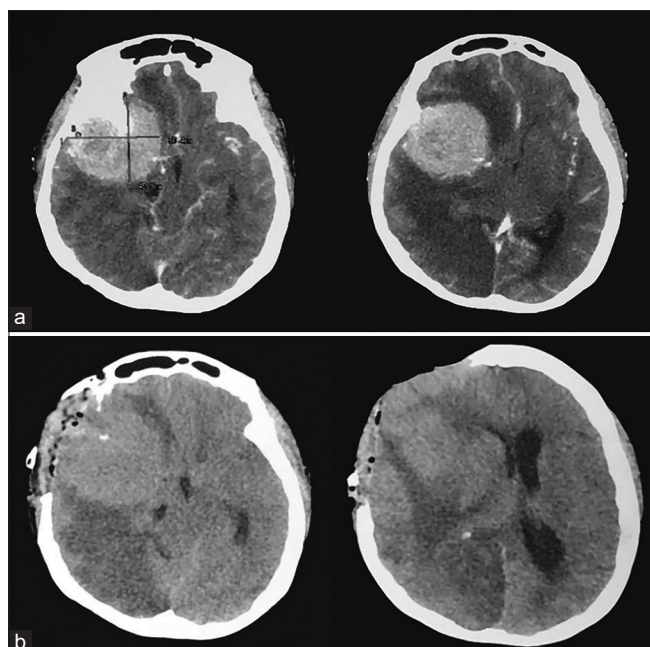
Head computed tomography scan of a 44-year-old woman with the consciousness decreases for 7 h before admission. (a) Head computed tomography scan with contrast revealed homogenous hyperdensity mass at the right sphenoid bone which caused midline shifting to the contralateral side. It was suggestive of a right lateral sphenoid meningioma. (b) Immediate postdecompressive craniectomy of head computed tomography scan without contrast. The right temporo-fronto-parietal bone of right sides had been removed. Cerebral infarction was observed in the right hemisphere
